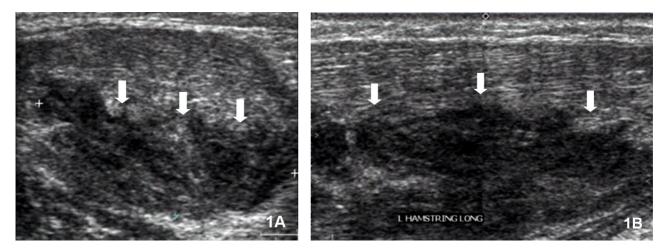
Ultrasonography of the right posterior thigh shows an ill-defined heteroechoic lesion (arrow) surrounded by a irregularly thick hyperechoic wall in the muscle layer. (A) transverse view, (B) longitudinal view.
